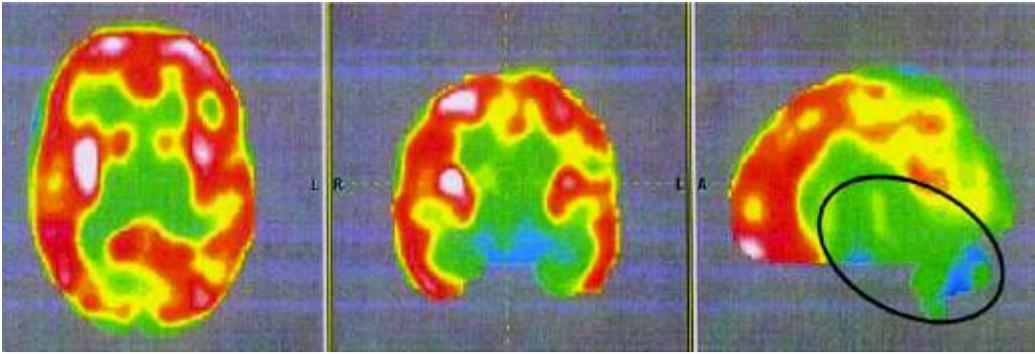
PET-CT scan after cellular transplantation showing increased metabolism in the regions of cerebellum bilaterally; indicated by reduction in the blue and black areas
